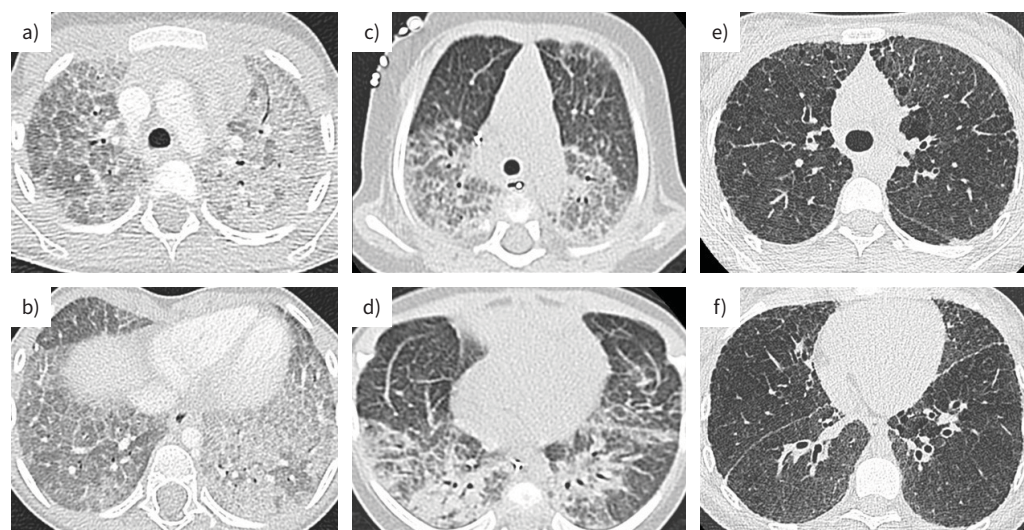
Computed tomography (CT) patterns associated with *CSF2RA* deficiency and *MARS* mutation. a and b) 6-year-old girl with *CSF2RA* deficiency. The CT scan reveals a diffuse crazy-paving pattern characterised by thickened interlobular septa and intralobular lines, superimposed with asymmetric ground-glass opacities, without zone predilection or gradient. Subsequently, almost complete regression of pulmonary alveolar proteinosis occurred after a phenoidentical bone marrow transplant. c and d) CT scan performed at the age of 2.5 months of a male with *MARS* mutation showing an anteroposterior density gradient with a crazy-paving pattern predominant in the posterior territories and distension in the anterior territories. e and f) The disease progressed to fibrosing interstitial pneumonia with CT at 12 years showing traction bronchiectasis and subpleural cysts with a honeycombing aspect.
